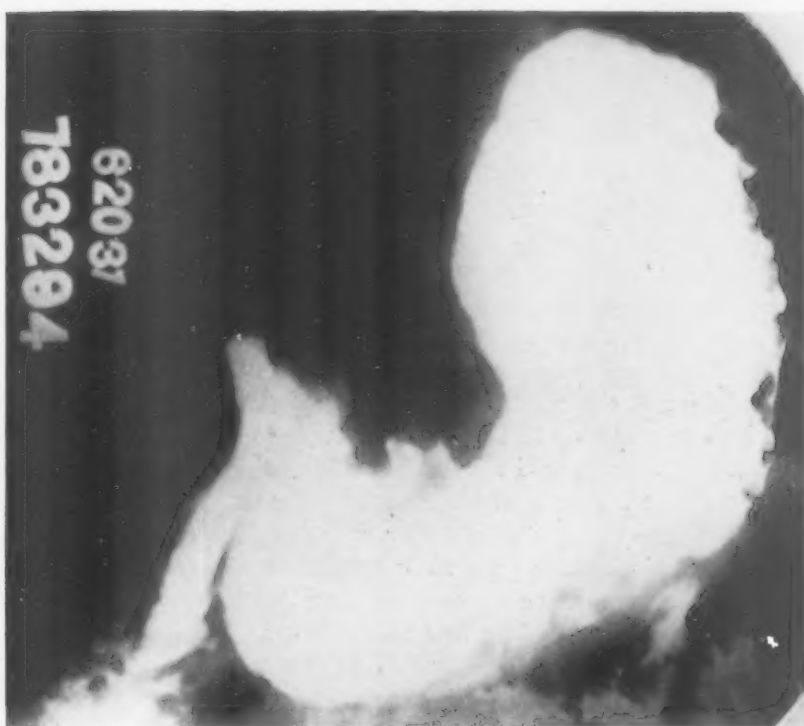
Pre-operative roentgenogram.
